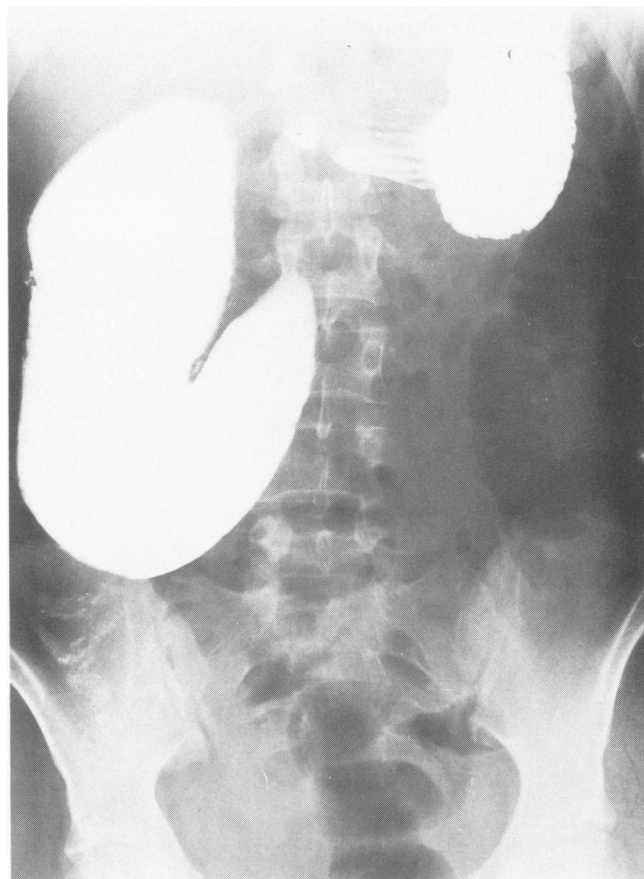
A typical upper gastrointestinal roentgenogram shows a dilated duodenum (Case 16).
